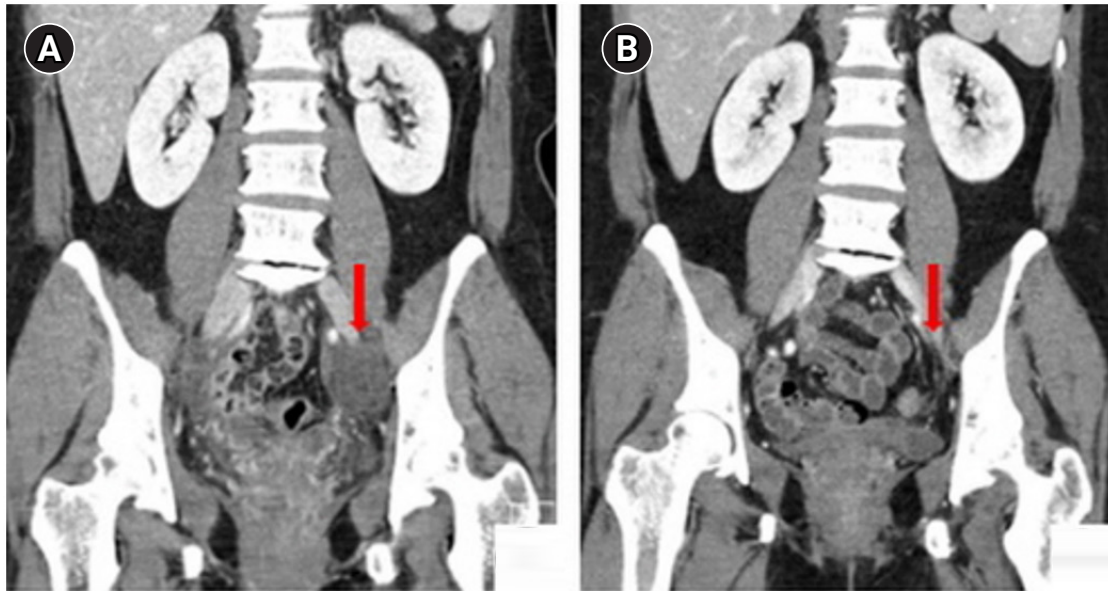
Abdominopelvic computed tomography scans. (A) Lymphocele (indicated by the arrow) at diagnosis. (B) After 4 months, we could confirm that almost the entire lymphocele (arrow) had been naturally absorbed.
